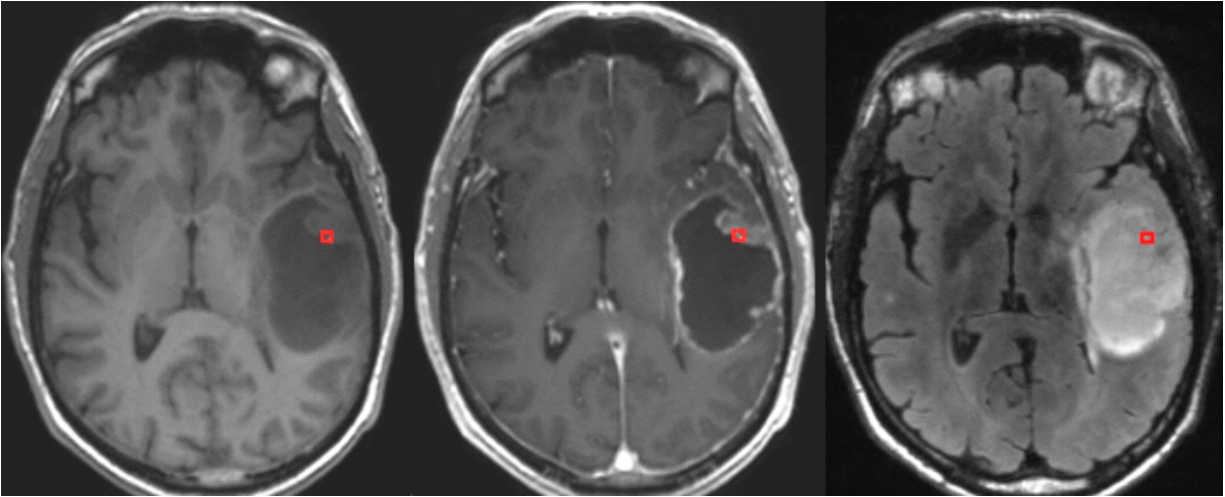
Anatomical MR images obtained from a patient diagnosed with GBM; (Left): a pre-contrast T1 image; (Middle): a post-contrast T1 image (T1-GAD); (Right): a FLAIR image; the region marked with red was later selected as a biopsy location
